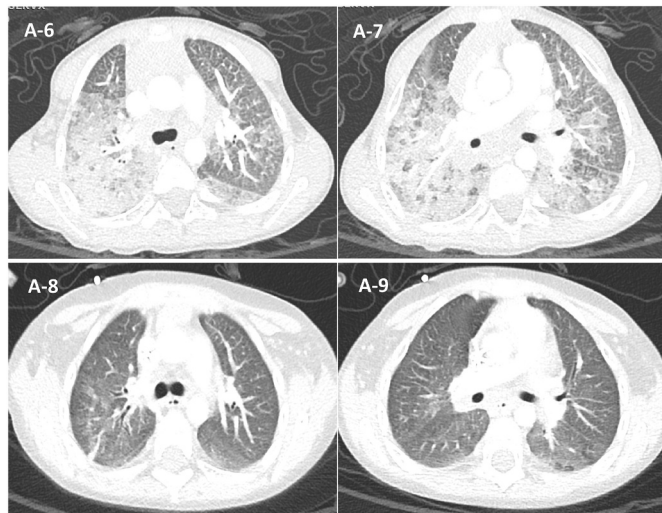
Chest CT of patient A.
